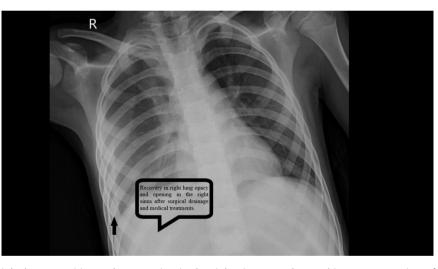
Recovery in right lung opacities and an opening in the right sinus are observed in X-ray screening of the lung after surgical drainage and medical treatments
